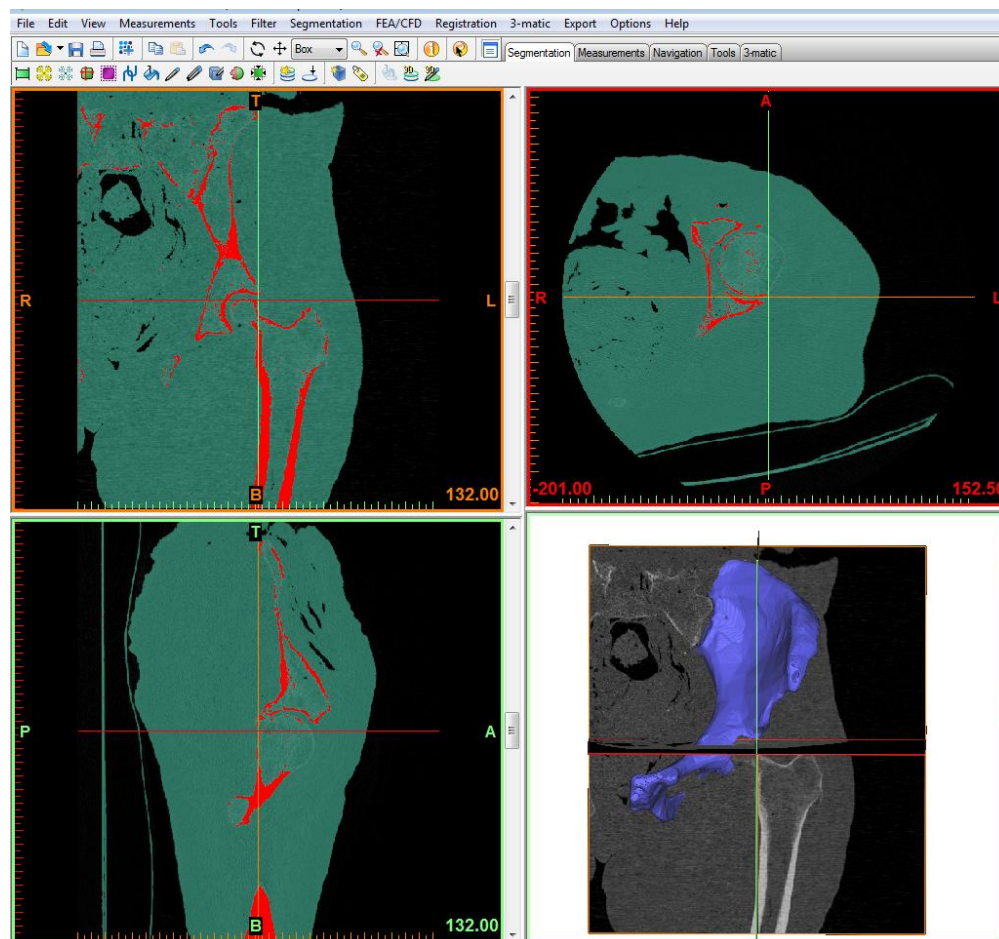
Figure XLIII. High resolution CT scan of the intact hemi-pelvis. Cortical and cancellous bone mask surfaces are automatically generated using density segmentation in Mimics.
